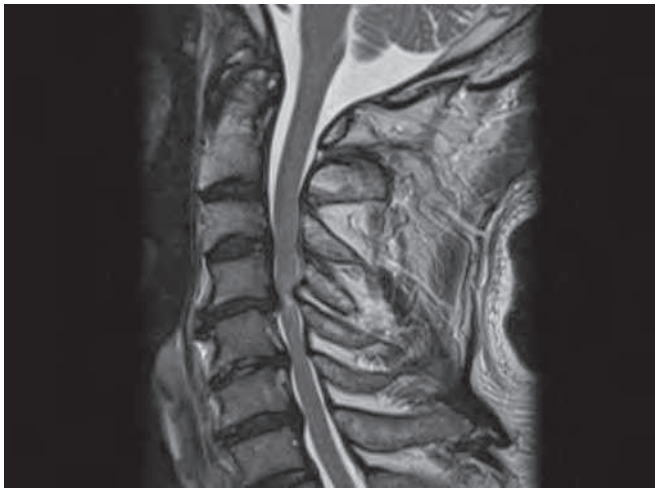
Sagittal T2-weighted MRI showing spinal cord compression at the C4-5 intervertebral level and a high-intensity signal change.
